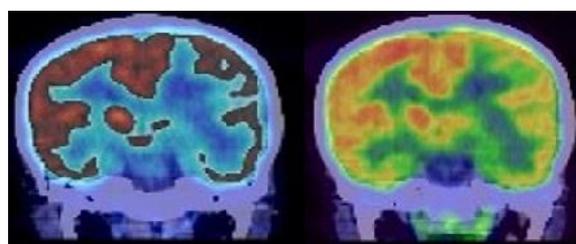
¹⁸F-FDG PET/CT in coronal section of brain show that left cerebrum appears bulky and distinction of the gyri and sulci are lost. There is relative hypometabolism on left side.
